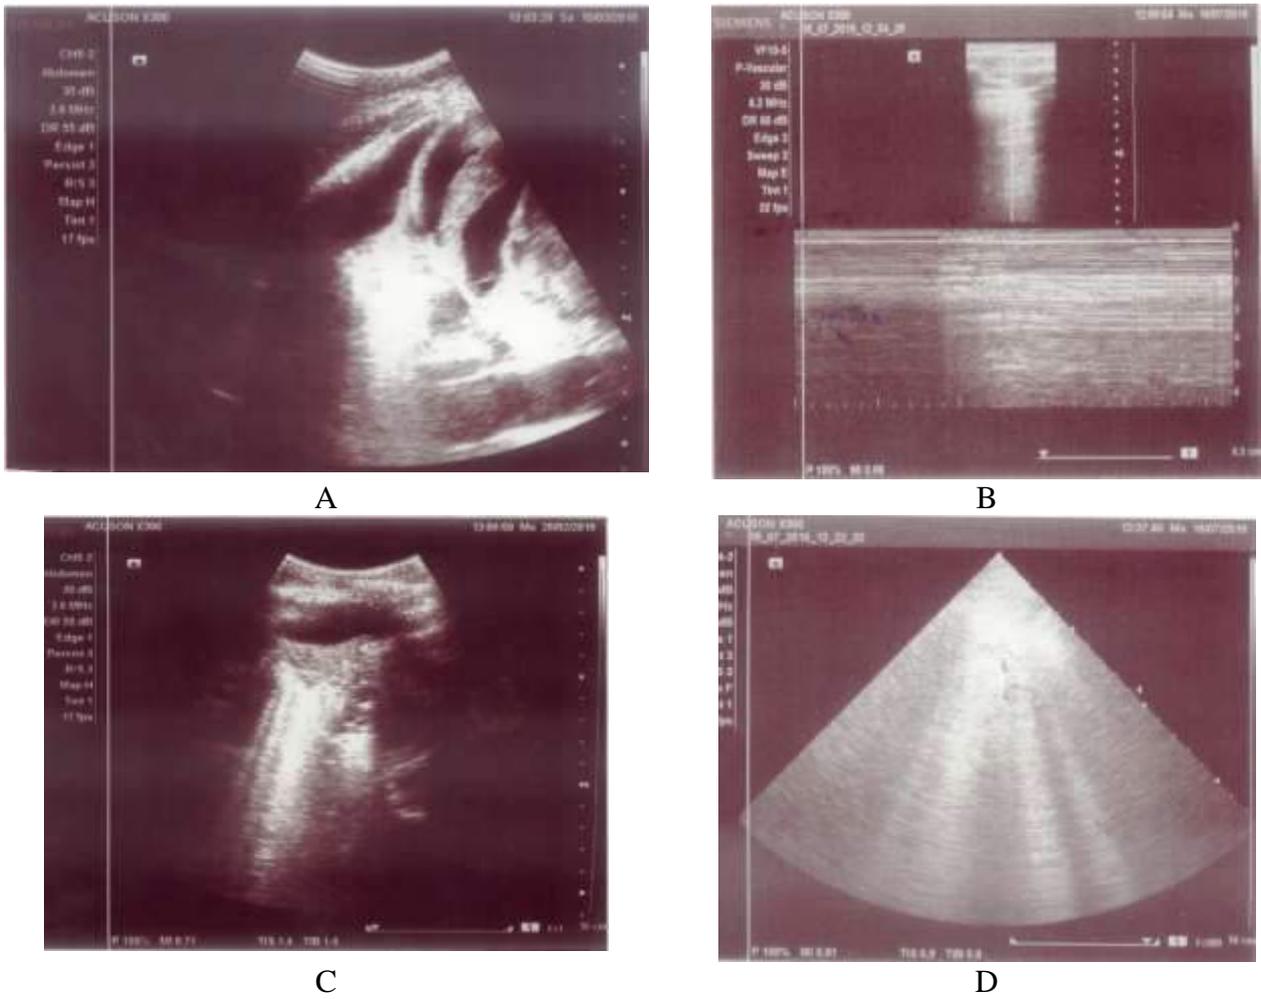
Lung ultrasound pictures from our patients: A: Septated pleural effusion, B: Lung point of Pneumothorax, C: Shred sign of pneumonia, D: B-profile of Pulmonary edema.
